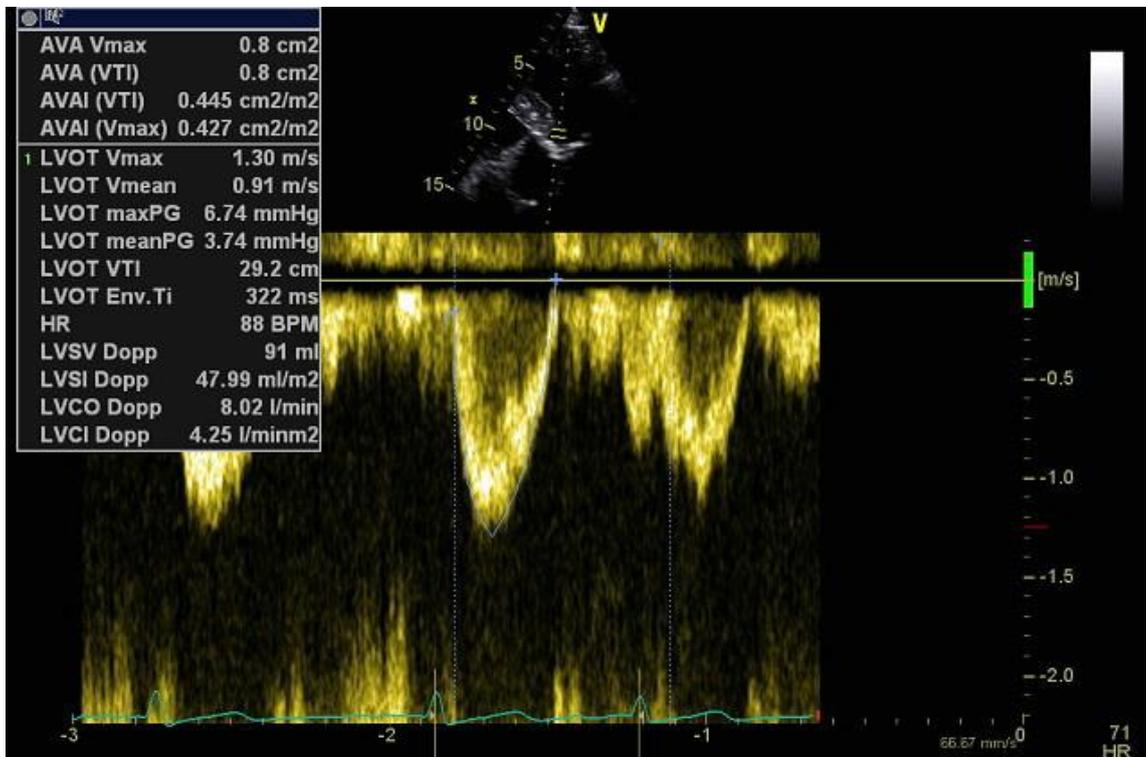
Pulse wave Doppler at the level of left ventricular outflow tract
